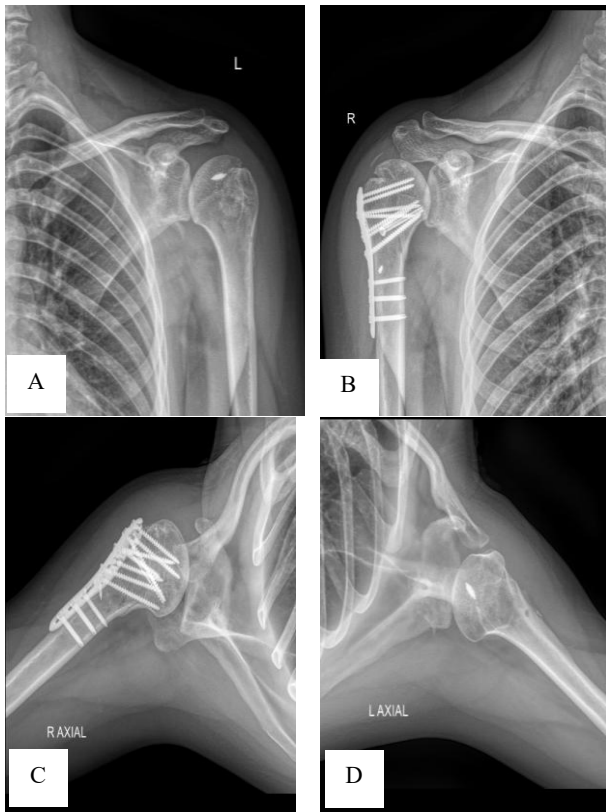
(A-D): Post-operative antero-posterior and axial X-ray images at 2 years follow-up showing well healed bilateral proximal humerus fractures, congruent reduction of shoulders with metallic implants in situ.
